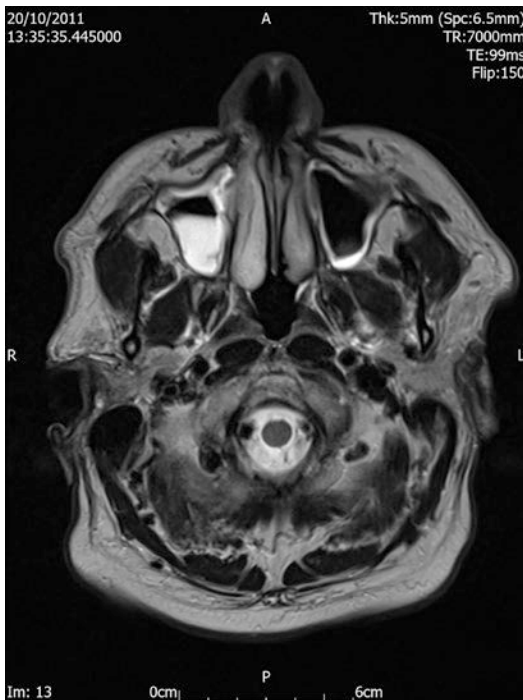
Postoperative T-2 weighted axial MRI scan demonstrating the total septectomy. There is fluid in the right maxillary sinus
